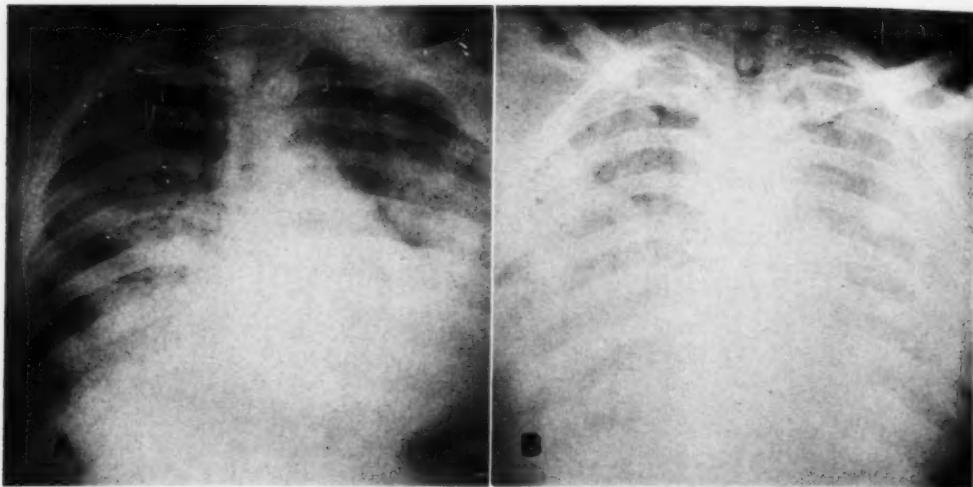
A. Roentgenogram (portable) obtained during the toxic stage of hemorrhagic fever, showing extensive pulmonary vascular congestion, with numerous areas of pulmonary edema.
